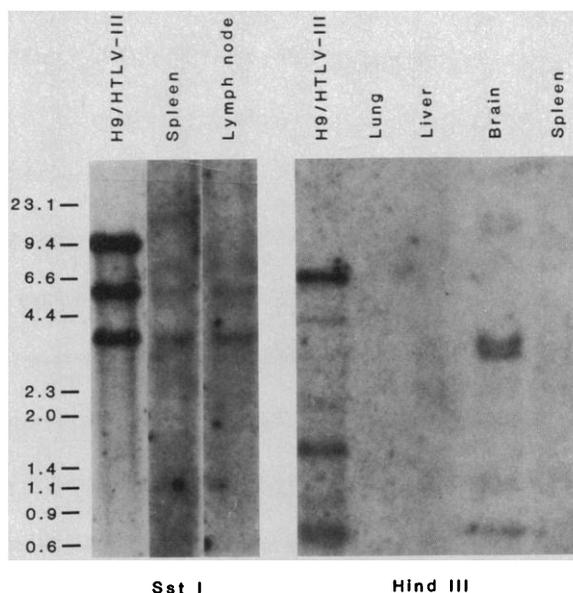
Detection of HTLV-III DNA in brain and other tissues from patient 3 (see Table 1 and lane a in Fig. 1). DNA was extracted from brain, spleen, lymph node, liver, and lung, digested with the indicated restriction endonucleases, and blot-hybridized as described (30). DNA (30 µg) from each tissue was used so that the relative abundance of HTLV-III DNA in each could be ascertained. DNA (3 µg) from the H9/HTLV-III cell line was included as a positive control [note that H9/HTLV-III cells each contain many HTLV-III molecules (9, 18)]. The Sst I blot (left) was exposed to x-ray film for 7 days whereas the Hind III blot (right) was exposed for only 1 day. This blot hybridization demonstrates that the abundance of HTLV-III was much greater in brain than in any of the other tissues from this patient.
